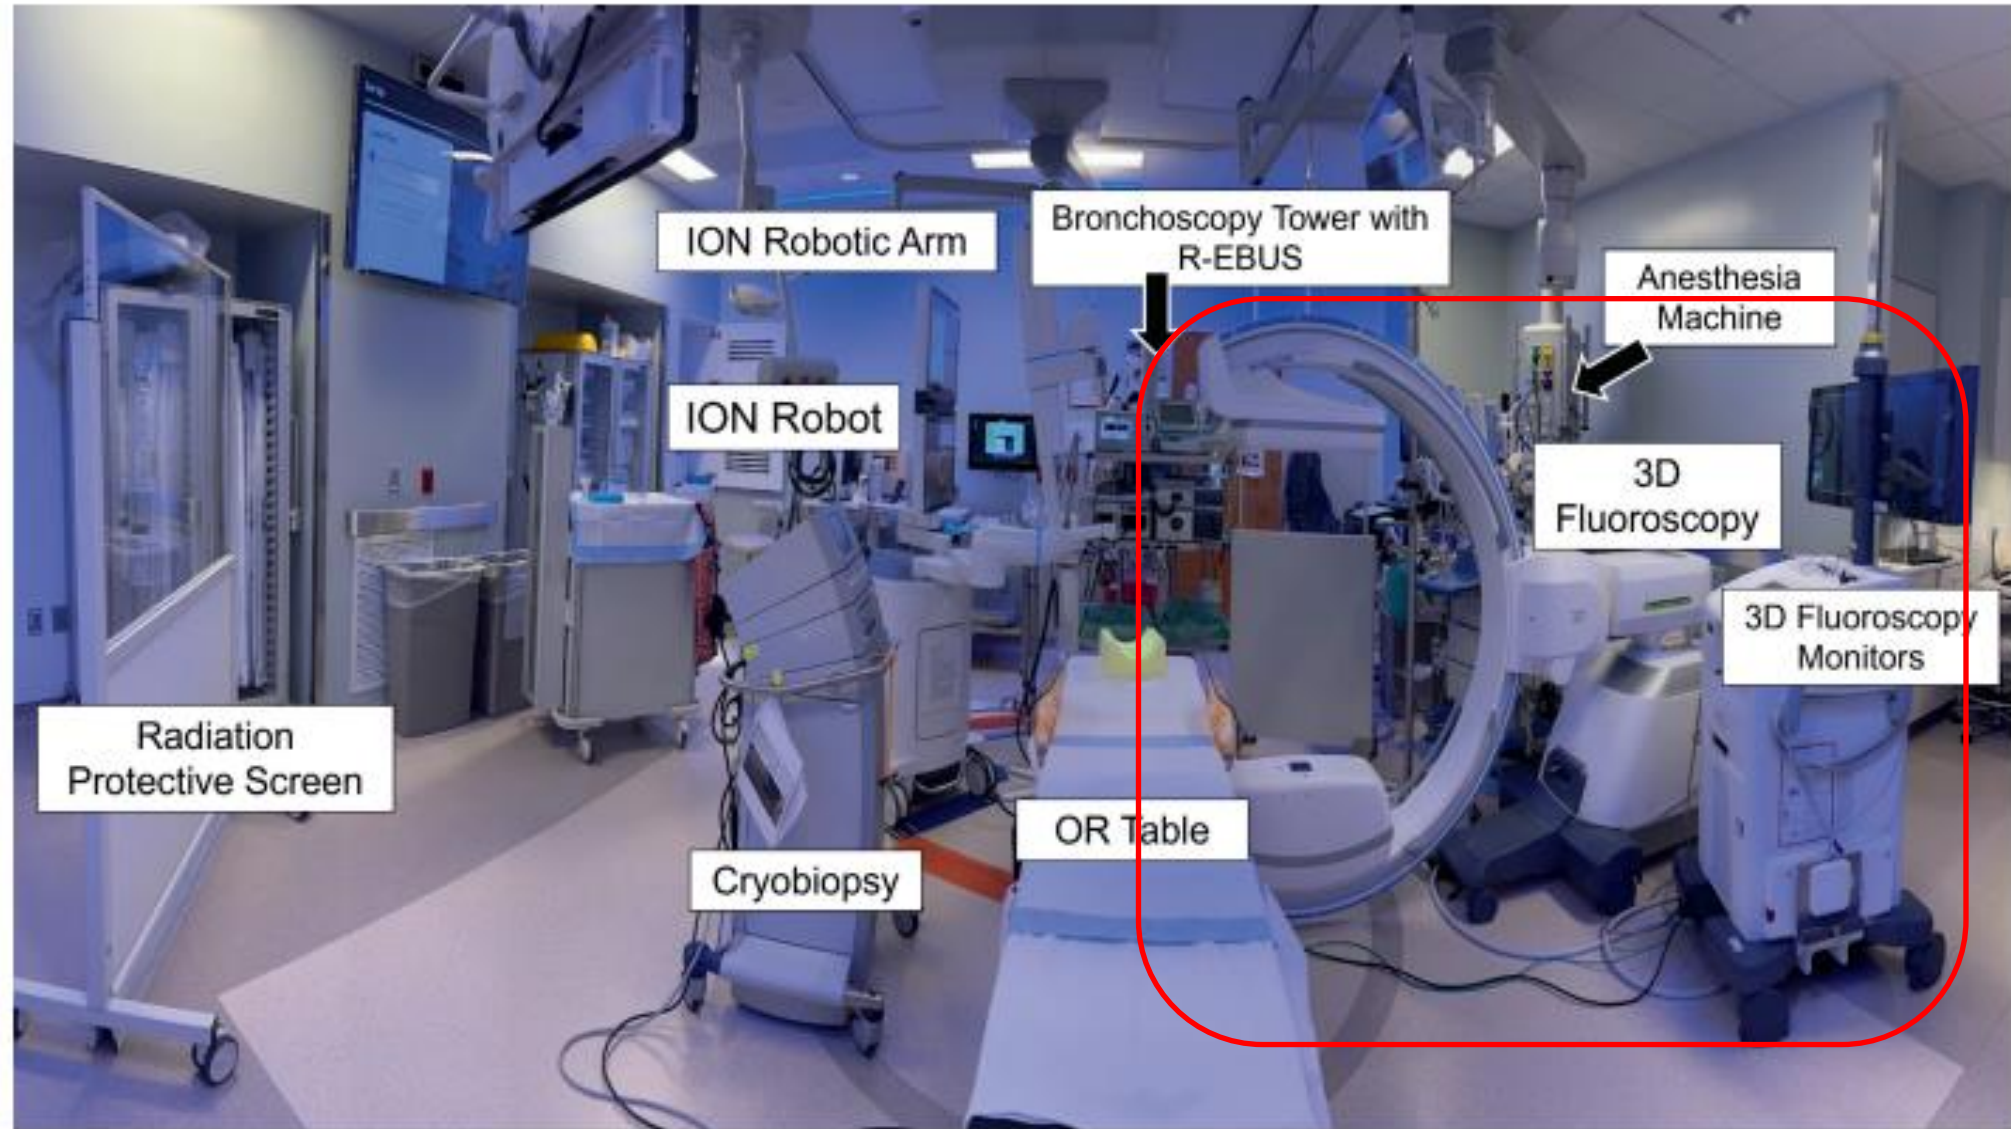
Bronchoscopy room set-up of Site 1 including shape-sensing robotic-assisted bronchoscopy, mobile cone-beam computed tomography and cryoprobe.
